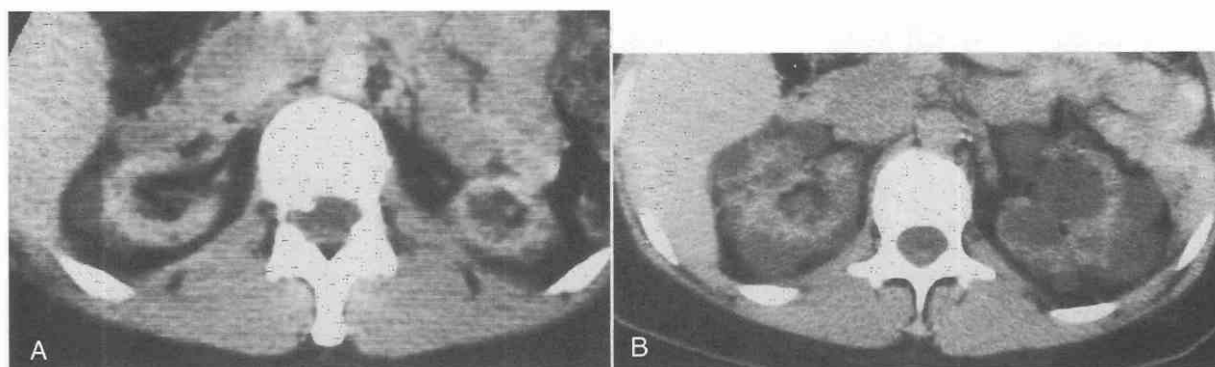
Acquired renal cystic disease in a 45-year-old man undergoing long-term hemodialysis. *A*, CT scan after 4 years of dialysis shows bilateral small cysts in shrunken kidneys. *B*, A follow-up CT scan obtained 4 years later shows enlargement of cysts and kidneys.
